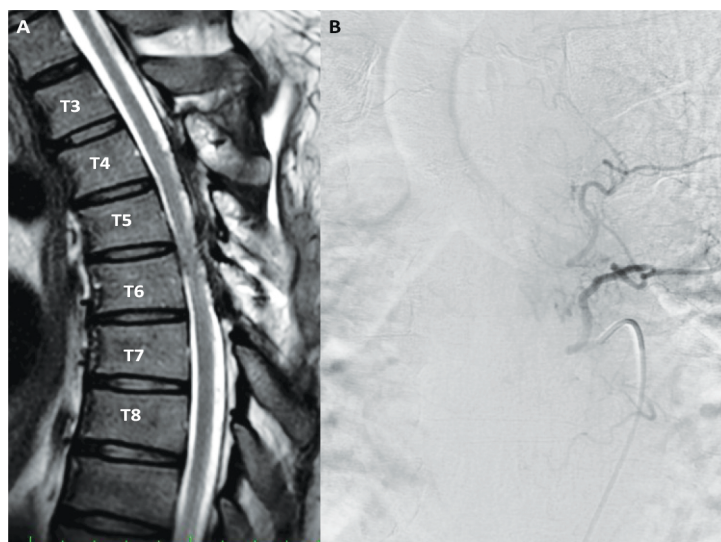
A: Post-operative MRI showed resolved cord oedema and dilated perimedullary vessels.
